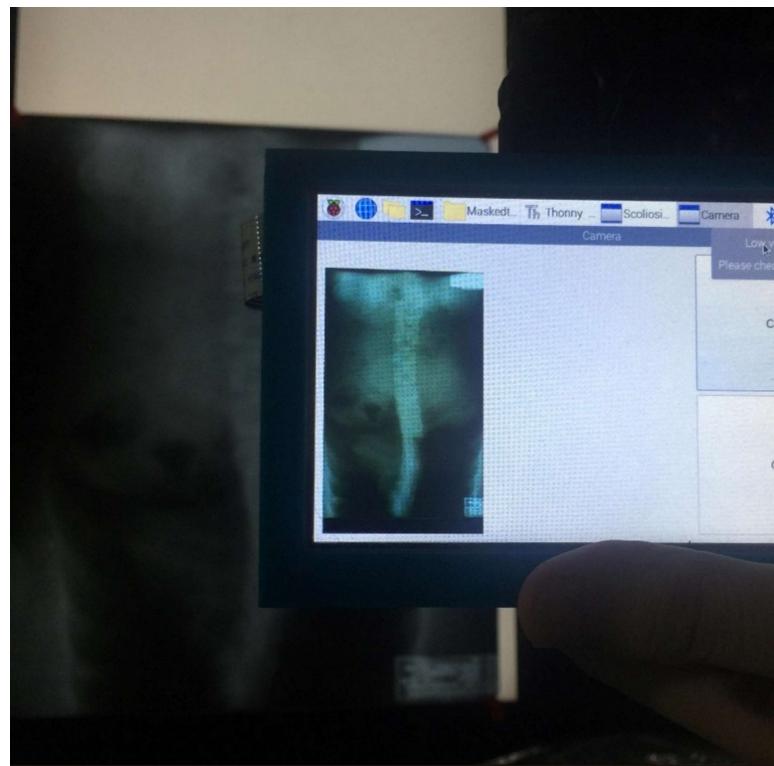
Taking a Photo of the X-ray Film
